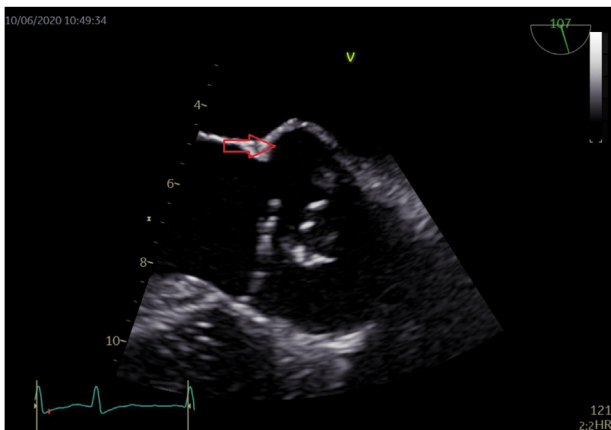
Transesophageal echocardiography of a patient with *Corynebacterium kroppenstedtii* endocarditis, demonstrating a large perivalvular abscess cavity (red arrow) suggestive of an endocarditis.
